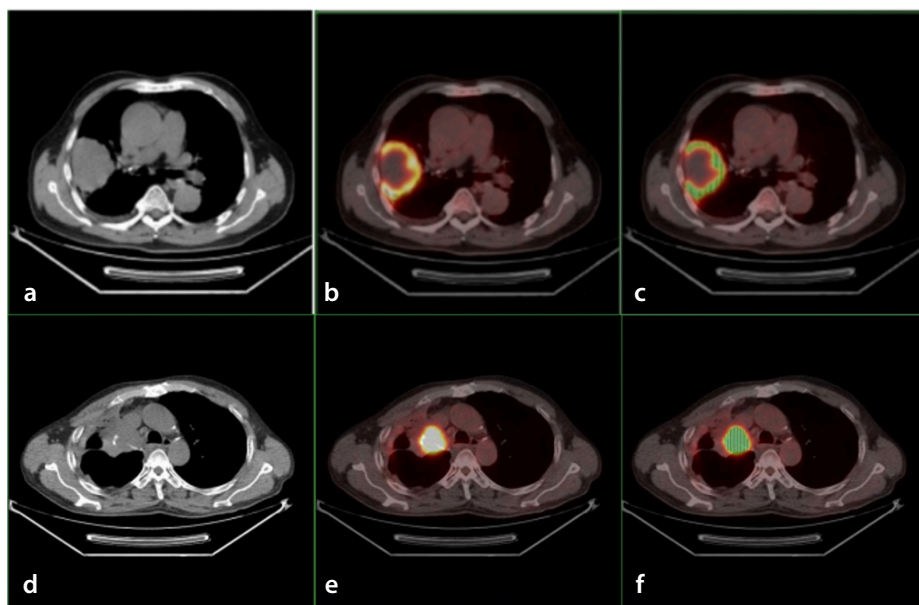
Metabolic distribution of lung lesions on positron emission tomography/computed tomography image. (a-c) An adenocarcinoma of the right upper lung; (d-f) postoperative recurrence of the right upper lung squamous cell carcinoma. Left: axial CT; middle: fused image; right: the biopsy area represented by green on the fused image.
